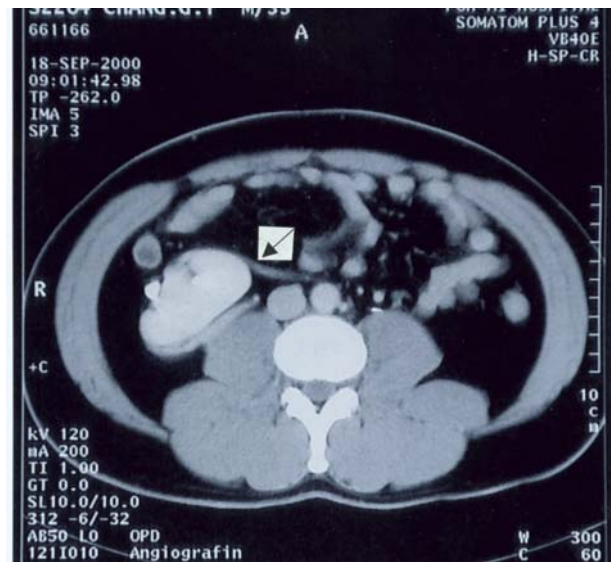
Abdominal CT scan showing a right laterally malrotated kidney with a circumferential course pattern where the renal artery (arrow) courses ventrally to the hilum.
